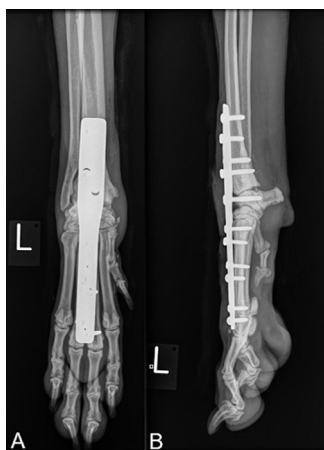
Immediate postoperative radiographs showing the arthrodesis plate and screws in place, without evidence of an ulnar fracture: (A) dorsopalmar and (B) lateral
